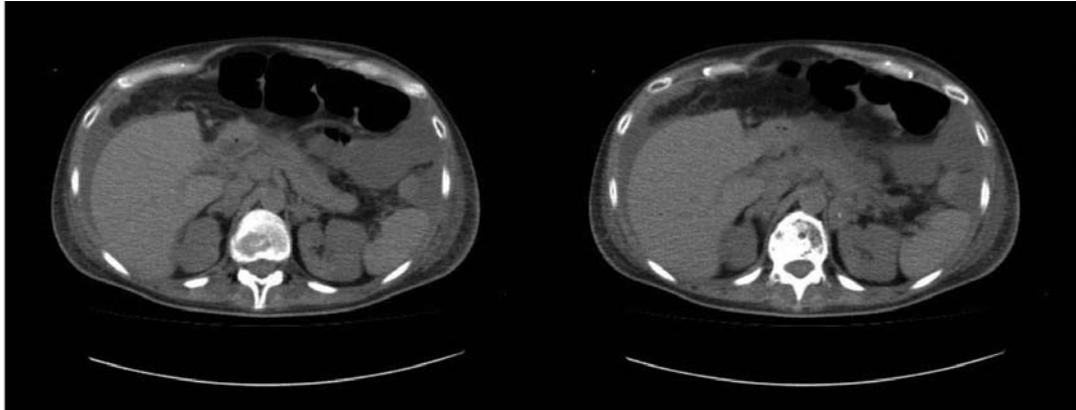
Computed tomographic findings of dilatation of the main pancreatic duct, peripancreatic fat stranding, and transverse colon dilatation with air during a pancreatitis bout in the patient.
